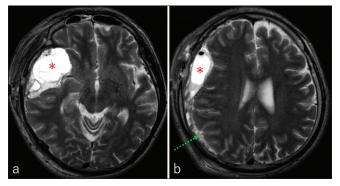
Axial T2-weighted, magnetic resonance imaging, performed on postoperative day 5, at the level of the (a) third ventricle and (b) upper lateral ventricle showing less compressive, extra-axial cyst in the right Sylvian fissure (asterisk), and satisfactory evacuation of chronic subdural hematoma (dashed arrow).
